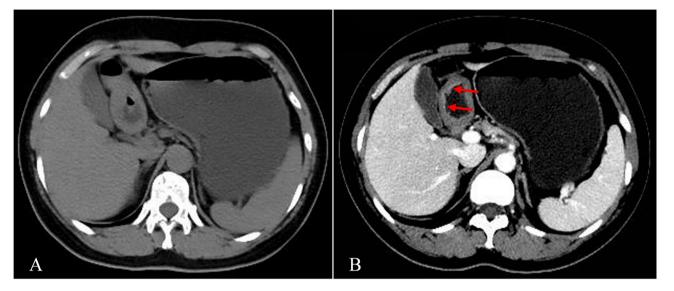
A typical case (female, 50 years old) with local gastric wall thickening with abnormal enhancement on CT (gastritis). (A) Plain CT image: Local gastric wall thickening in the lower 1/3 of the stomach. (B) Enhanced CT image: The lower 1/3 of the stomach had abnormal enhancement (red arrows).
